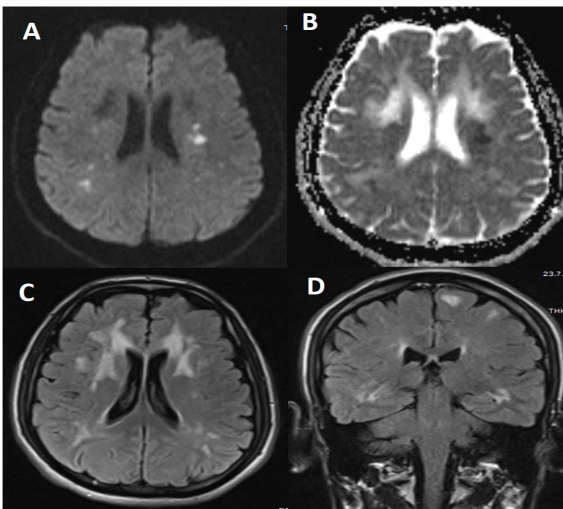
Diffusion Weighted magnetic resonance imaging (DWI- MRI) and FLAIR imagings; multiple hyperintensities in bilateral subcortical white matter with low ADC values (A,B); diffuse leucoencephalopathy involving temporal lobes (C,D)
